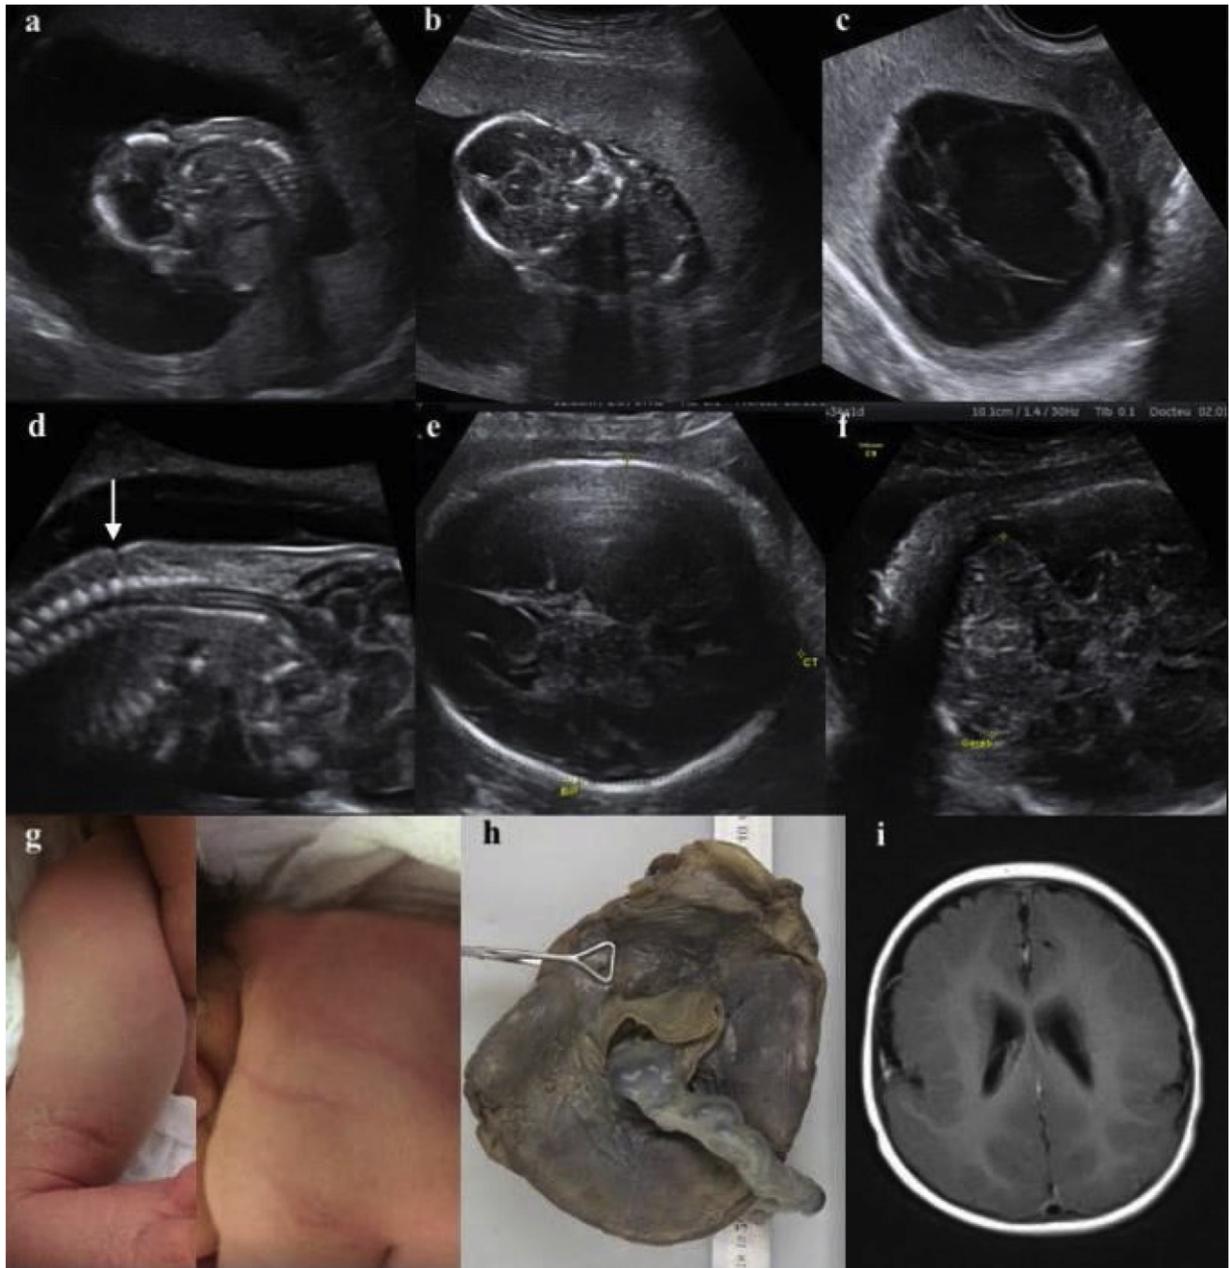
a–c : 14 Weeks of Gestation (WG) : limbs in a state of hyperflexion, permanent rotation of the fetal head in an unusual axis, multiple linear bands surrounding the fetus visualized vaginally; Figure d : 18 WG, suspect dorsal cutaneous furrow; Figures e–f : 29 WG: fetal brain imaging seems normal; Figure g: striations at the left ankle and left shoulder; Figure h: macroscopic examination of the placenta; Figure i: Magnetic Resonance Imaging at the age of 8 months: polymicrogyria.
